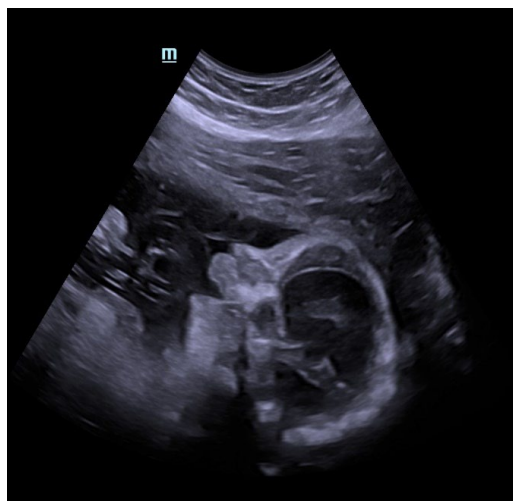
Retrognathism on ultrasound.
